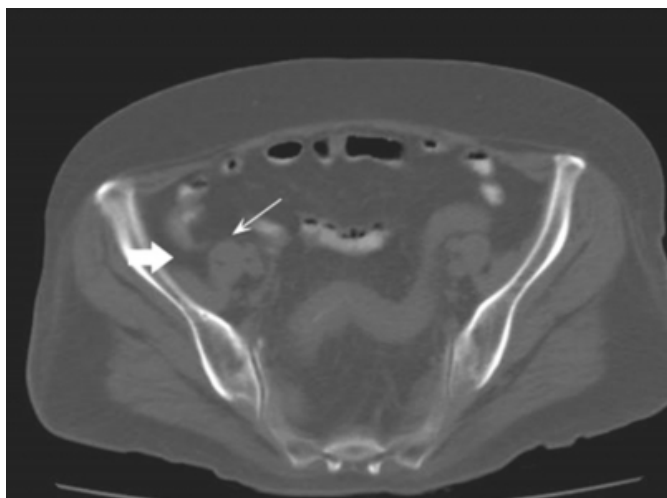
CT axial non contrast image demonstrating air pockets (arrows) in the fistulous tract.
